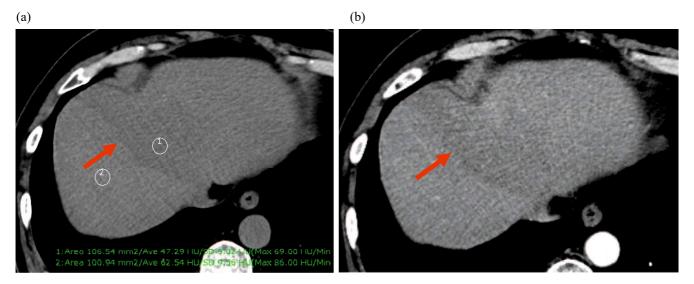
A 65-year-old man with left lobar steatosis. a) Unenhanced CT and b) arterial-phase CT show predominant hepatic steatosis of the left hepatic lobe (arrows). CT attenuation values of the right and the left hepatic lobe on unenhanced CT were 62.5 and 47.3 HU, respectively. Contrast enhancement value of the areas of left lobar steatosis was slightly lower than that of the non-fatty right lobe.
